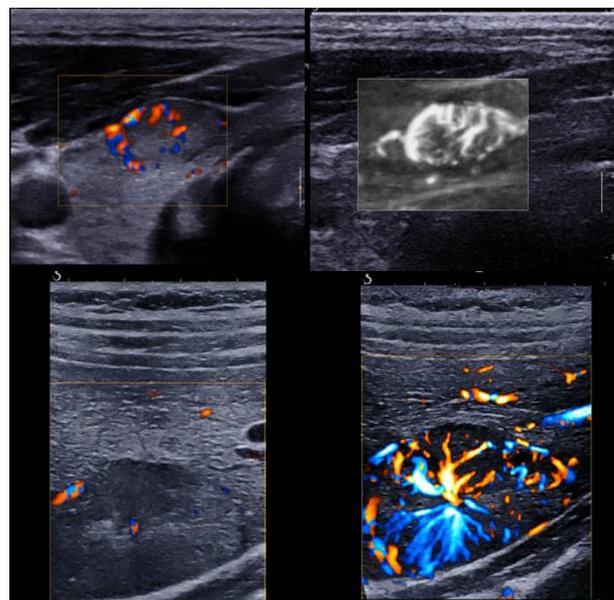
Example of sensitive ultrafast Doppler (Angio Plus) compared to classical Doppler o clinical cases: thyroid nodule (up) and transplanted kidney (bottom)
